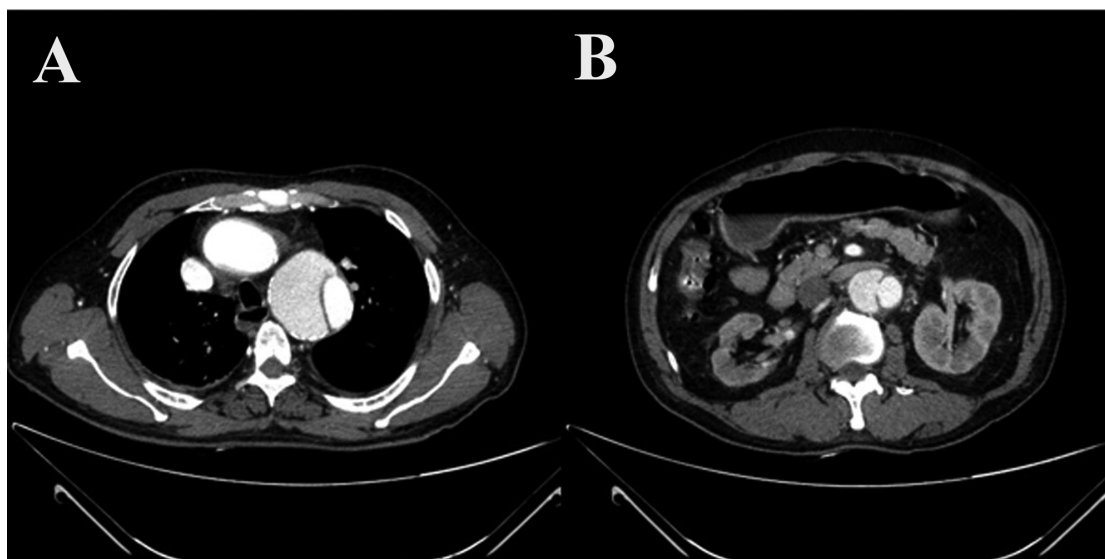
Computed tomography revealed an aortic dissection with entry and re-entry tears.
